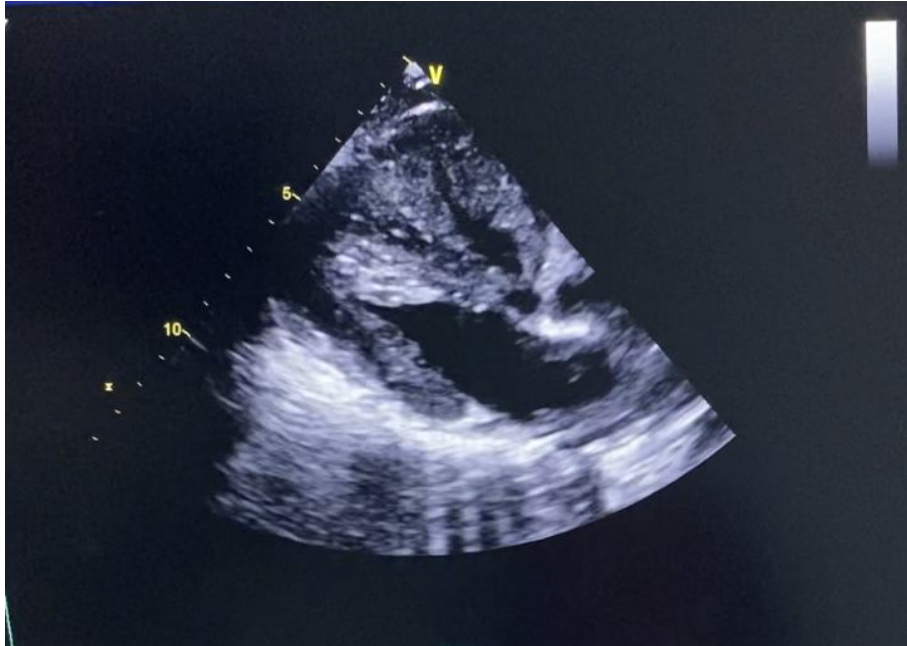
Parasternal long axis view echocardiography showing the mass of the RV
